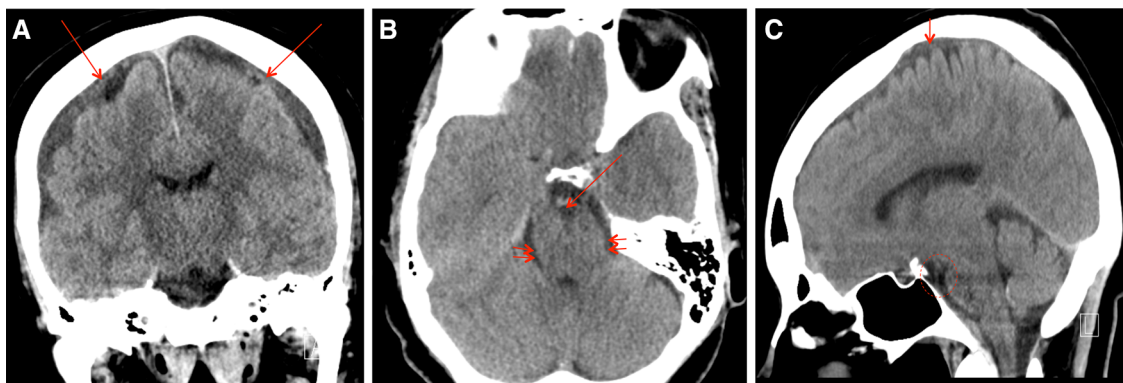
CT brain without contrast. a Coronal view shows bilateral subdural, heterogeneous collections. b Axial view shows small interpeduncular (arrow) and ambient (double arrow) cisterns.
